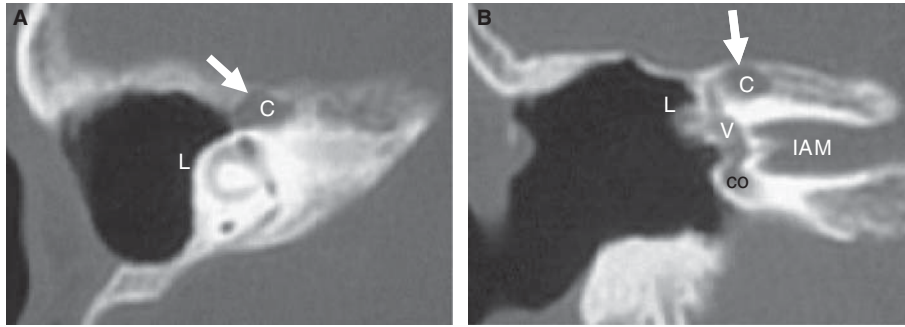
Case 3. CT (axial and coronal) before surgery. Round soft tissue density (arrow) medial to the SSCC. C, cholesteatoma; co, cochlea; IAM, internal auditory meatus; L, lateral semicircular canal; V, vestibule.
